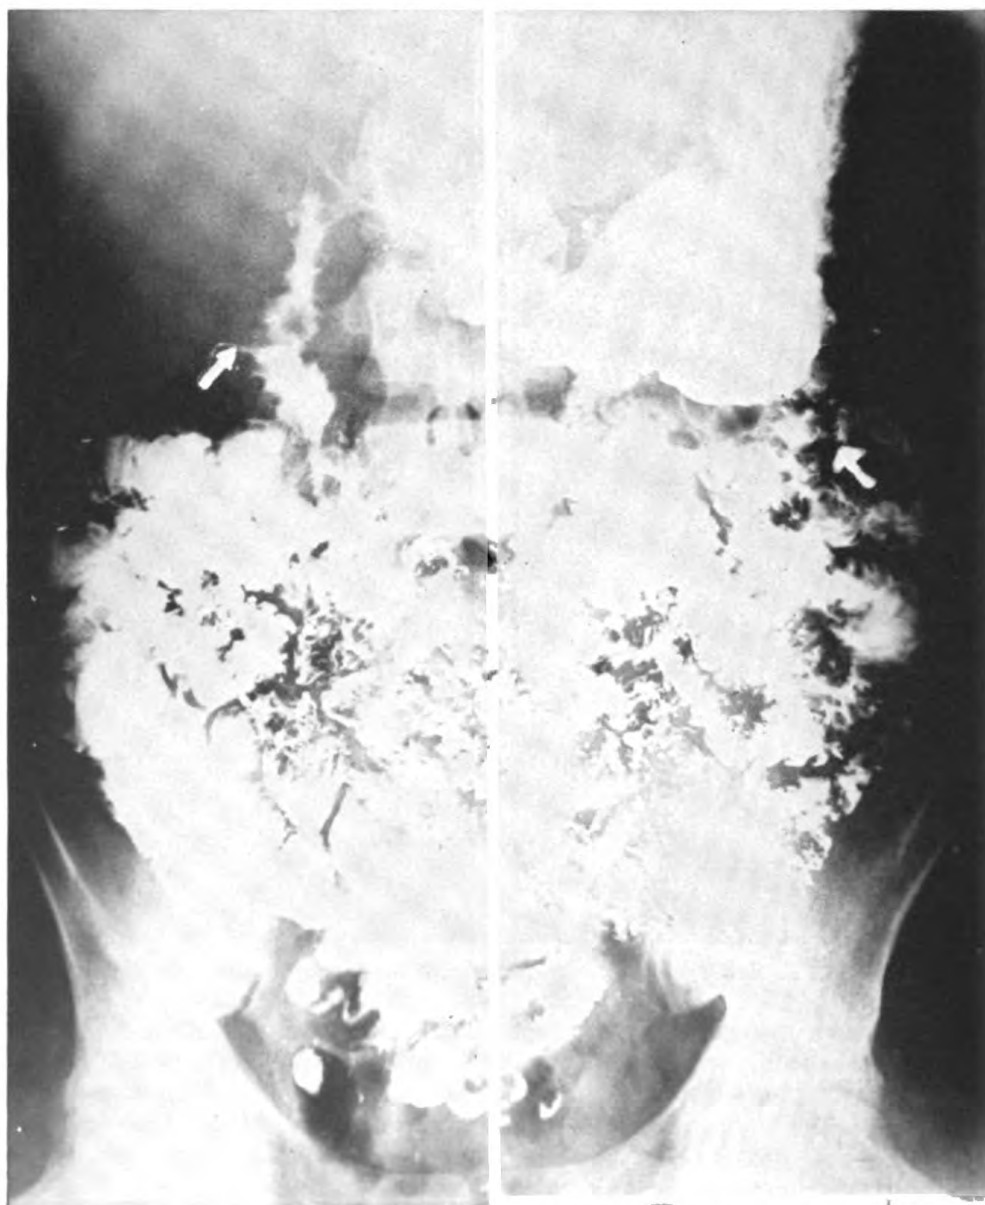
Roentgenogram of barium meal 30 minutes following ingestion. The arrow points to the narrowed and spastic duodenum. Another arrow points to the persistent deformity along the greater curvature of the stomach in the fundal area.
